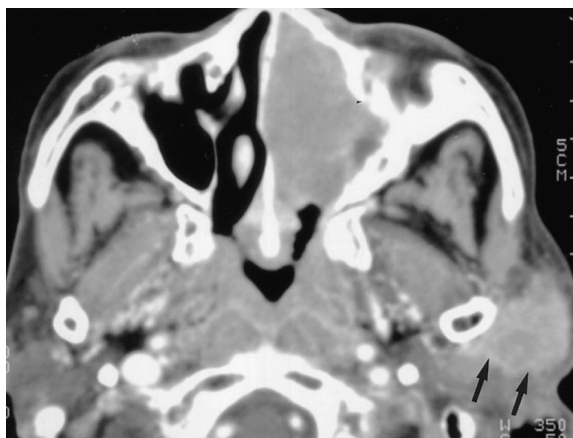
Intraparotid lymphoma in a 48-year-old woman. Transverse CT scan obtained after injection of contrast material shows a large, irregular, well-enhancing soft tissue mass (arrows) in the left parotid gland. A large, destructive soft tissue mass in the left maxillary sinus and soft tissue fullness in the nasopharynx are also seen.
